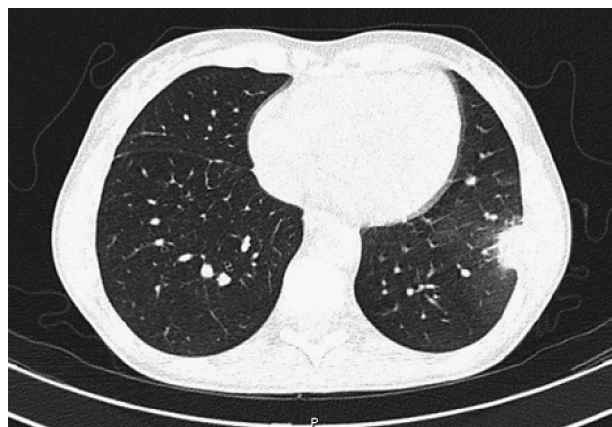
Computed tomography of the chest organs with intravenous bolus contrast-enhanced: focal consolidation in the lower lobe of the left lung (pulmonary infarction localized in S_8)
